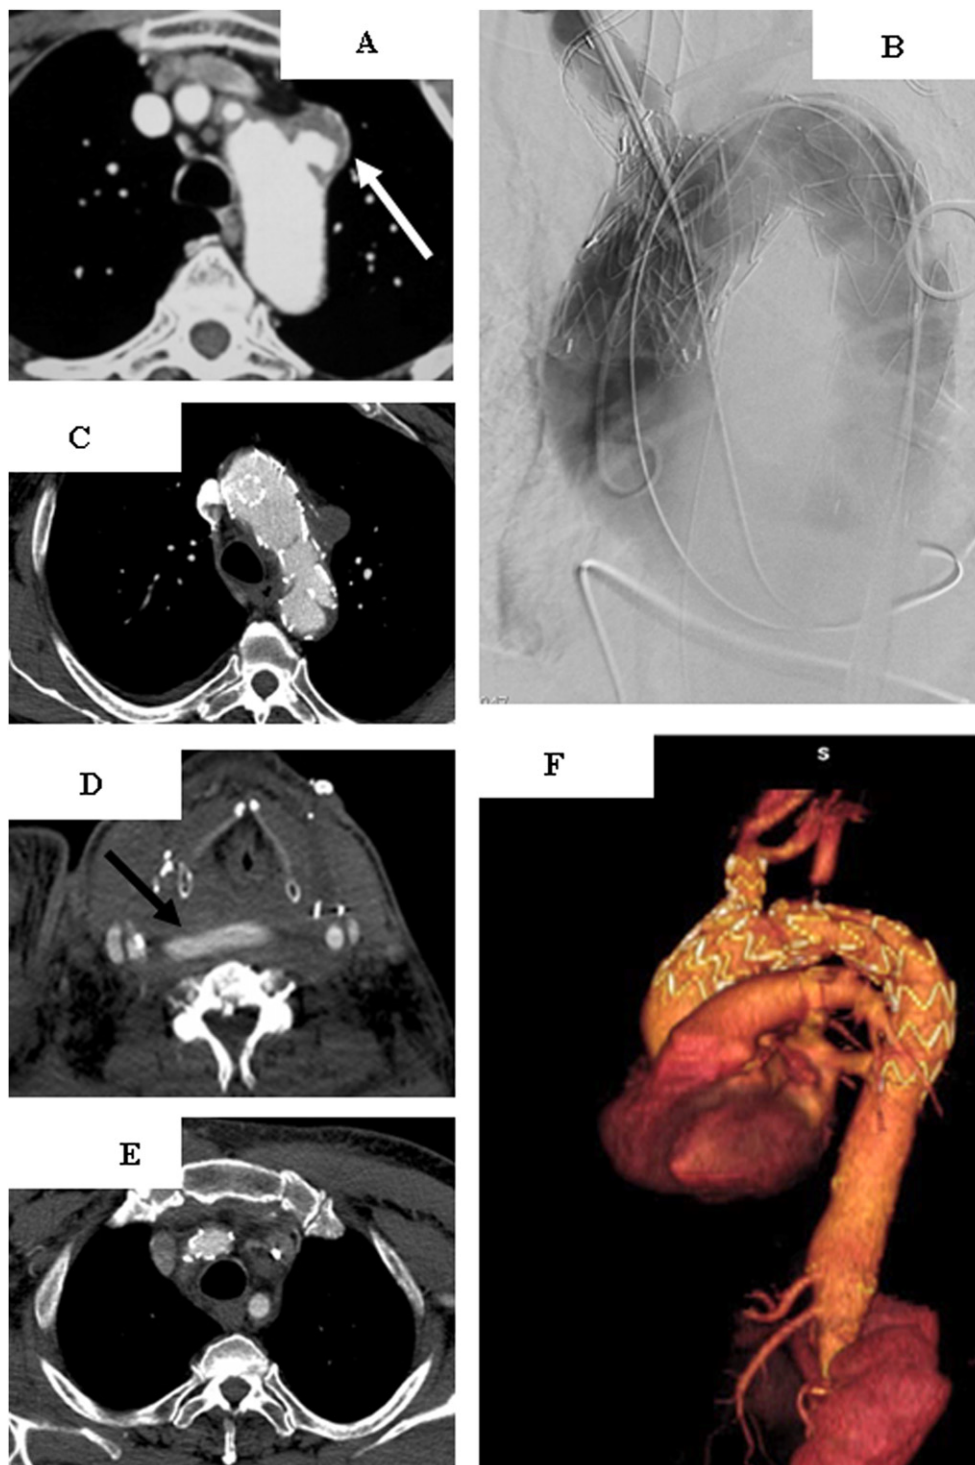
Case imaging. Preoperative angio-CT scan of the thoracic aorta showed a PAU immediately after the left subclavian artery (white arrow in A). Supra-aortic vessels originated from the arch, very close to each other (A). The angiographic control at the end of procedure showed a good result, absence of endoleaks and no prosthetic migration (B). CT-scan performed at discharge showed PAU thrombosis (C), patency of CCB (D), correct positioning of the branched stent-graft (C and E), thrombosis of the left common proximal carotid artery, patency of LSA due to retrograde perfusion in absence of significant endoleaks (E). CT-scan reconstruction of the thoracic aorta was performed after 1-year follow-up and confirmed a satisfactory result (F).
